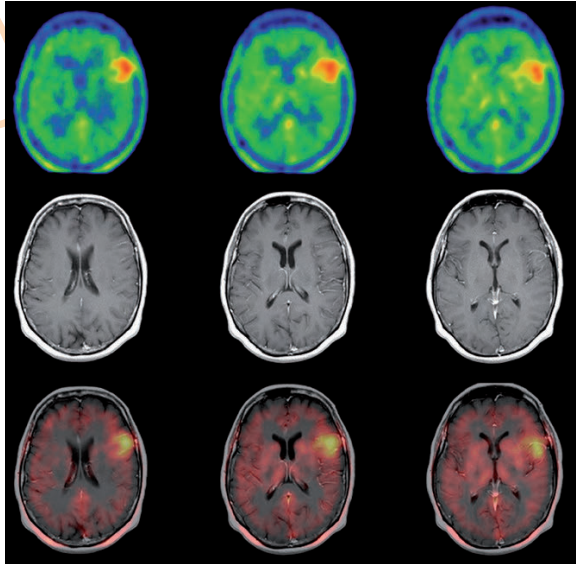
Amino acid PET (in this example with  $^{18}\text{F}$ -FET) also reliably depicts low-grade tumours in the majority of cases based on increased amino acid transport. Thus, it helps to define the metabolically most active area for biopsy planning even in cases where standard MRI shows only minor changes
